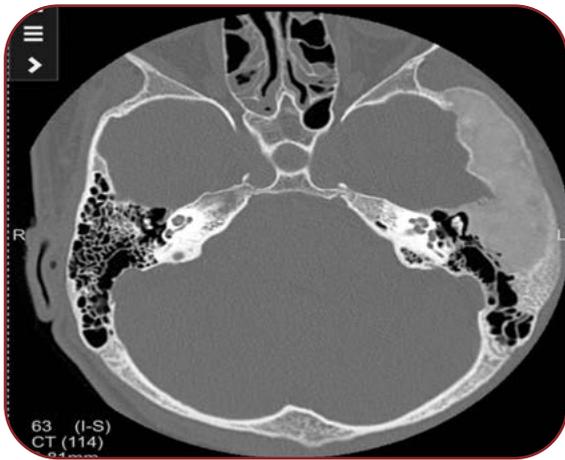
Computed tomography showing expansive thickening of the left temporal bone like ground glass matrix
